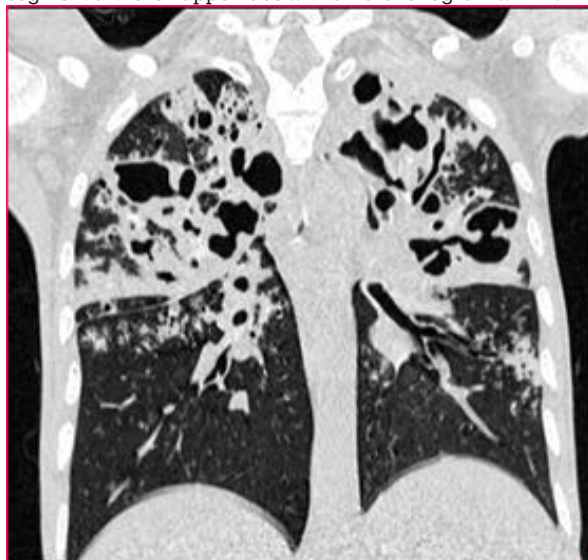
CT thorax lung window in Coronal view demonstrating multiple cavities, areas of parenchymal destruction, and associated fibrotic changes (17.2%) seen predominantly in bilateral upper lobes.
